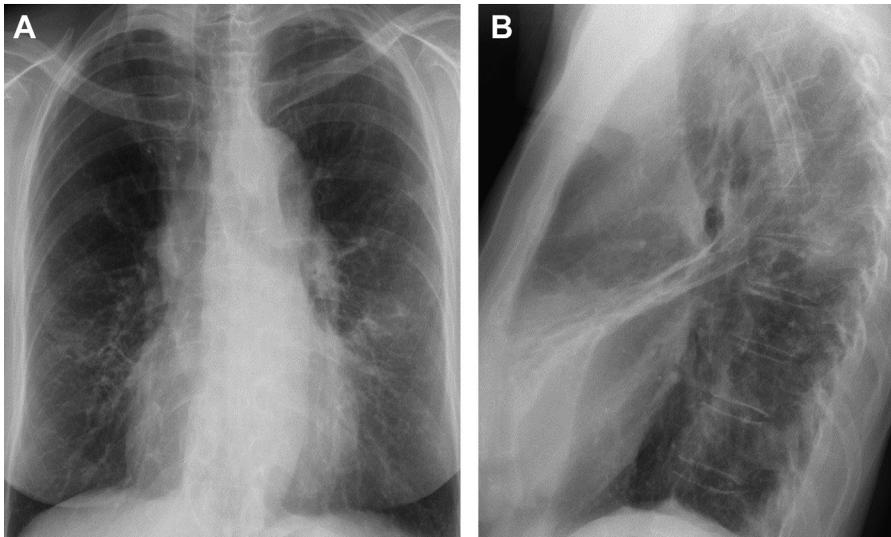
69-year-old woman with MAC. (A) Frontal and (B) lateral chest radiographs show areas of atelectasis and scarring in the right middle lobe and the lingula with bronchiectasis.
